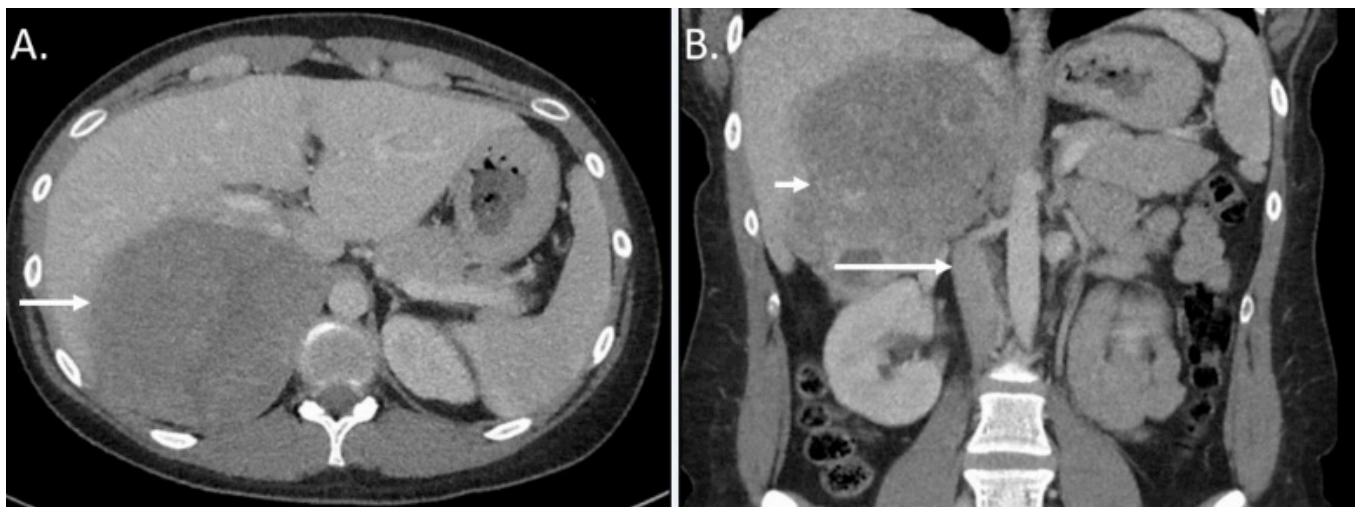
CT abdomen and pelvis with intravenous contrast. A.) Axial images demonstrating an 11 cm, heterogenous adrenal mass (white arrow). B.) Coronal images showing the tumor (short white arrow) abutting the inferior vena cava (long white arrow), right hepatic lobe, and right kidney.
